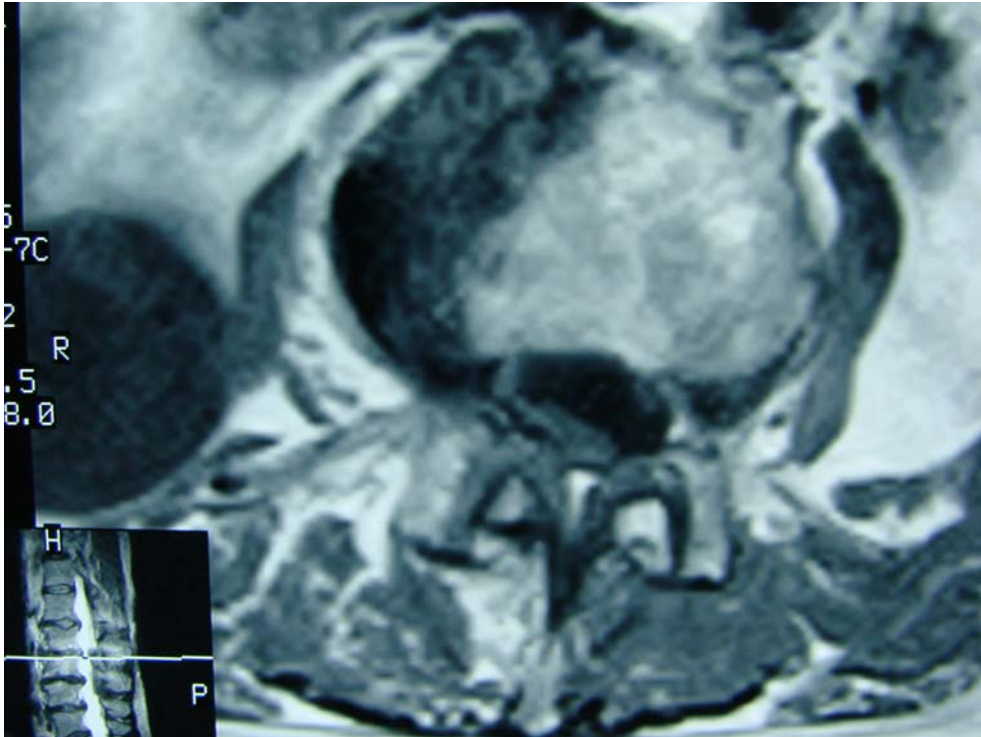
is the axial MRI image at the L2-L3 level showing the deformed spinal canal due to the scoliosis and the advanced discogenic changes resulting in posterior and lateral endplate hypertrophy and ligamentum flavum hypertrophy with facet arthrosis resulting in marked spinal and osseoligamentous canal stenosis.
